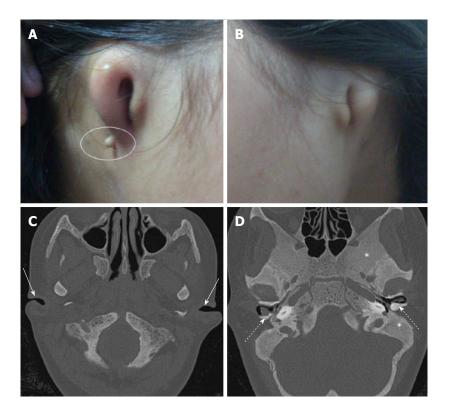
Bilateral dysplastic pinnae. Note preauricular skin tag on right side (circle). Axial HRCT (C and D) showing bilateral mild narrowing of cartilaginous EAC (arrows) and normal bony EAC (dotted arrow) with ear wax. Also seen are the thickened sclerotic calvarial bones with loss of normal medullary cavity (asterisk). EAC: External auditory canal.
